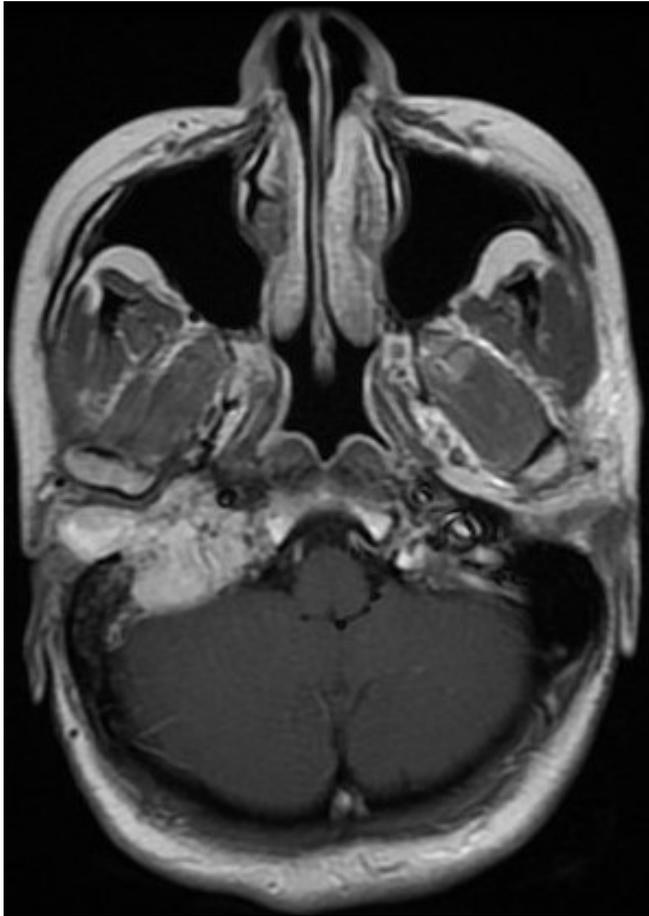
MRI: jugulotympanic paraganglioma
